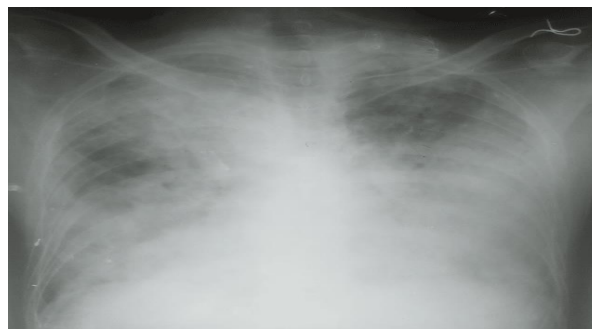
Progressive massive fibrosis on PA view of Chest x-ray.
